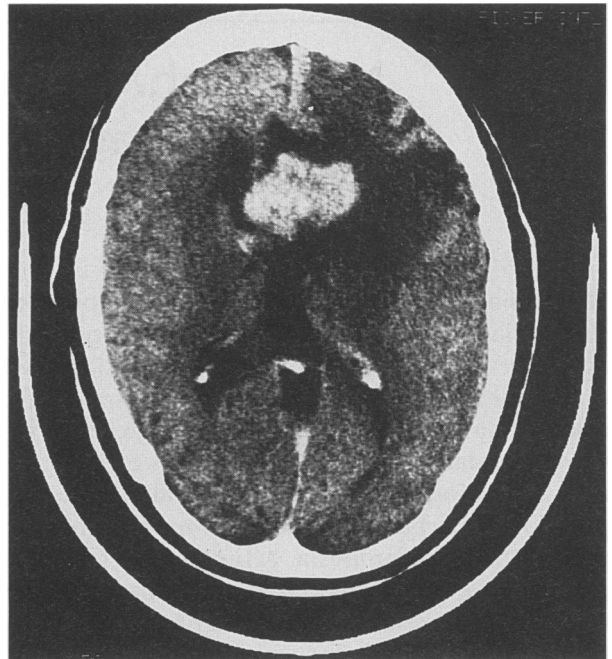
Frontal lobe tumor. Patient 2 presented with personality change from his lymphoma that involved both medial frontal lobes and crossed the corpus callosum, as seen on this enhanced computed tomographic scan. Extensive low-density edema surrounds the tumor.
